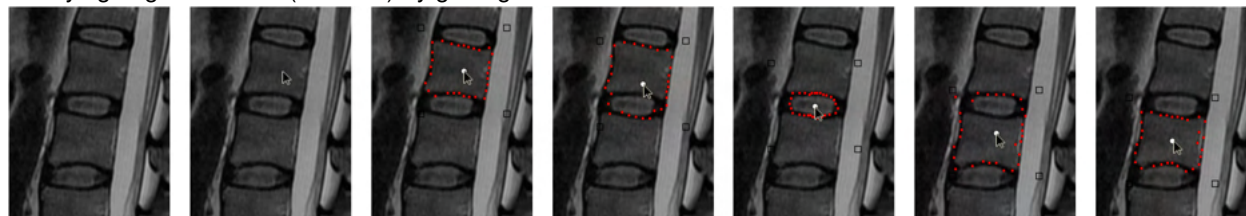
From left to right: several screenshots from a video demonstrating our interactive *real-time* segmentation for vertebral bodies and intervertebral discs in a sagittal plane of a MRI scan. The white dot is the graph's center point, the black boxes define the corners of the square template and the red dots are the segmentation outcomes.
